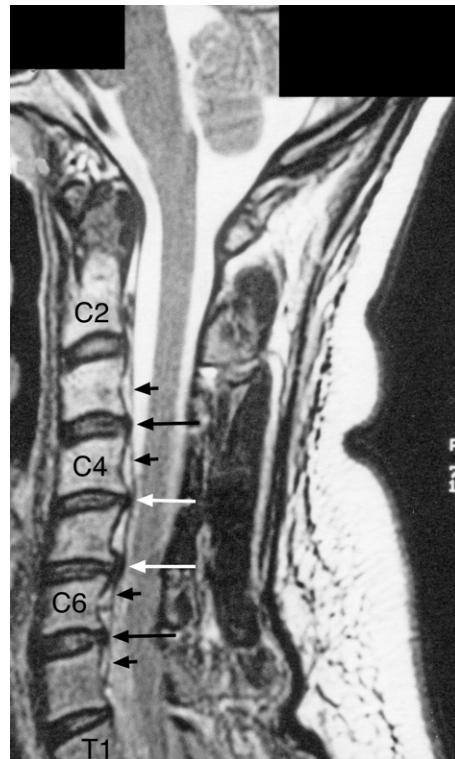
Cervical spine MRI sagittal T2-weighted image. Note the 'disc pathology at C4-5 and C5-6 with some bulging of both discs (white arrows) and early osteophyte formation. It appears that there is also disc bulging at the C3-4 and C6-7 levels (large black arrows). Also, the posterior disc bulges/protrusions at C3-4, C4-5, C5-6 and C6-7 press upon the pain sensitive anterior part of the dural tube (small black arrows). It is important to note that there is desiccation of the C3-4, C4-5 and C5-6 intervertebral discs, and to a lesser degree at the C6-7 disc level.'
